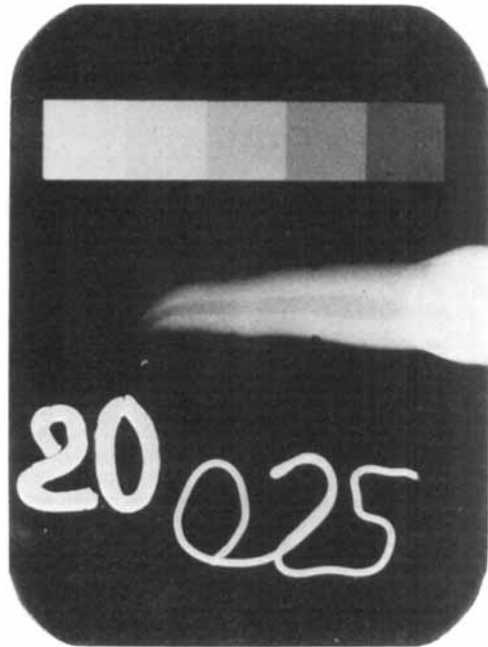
Roentgenogram of an extracted tooth with orientation notches mesially and distally. Beside it are the images of the penetrometer and of lead numerals indicating the tooth number and the exposure time.
